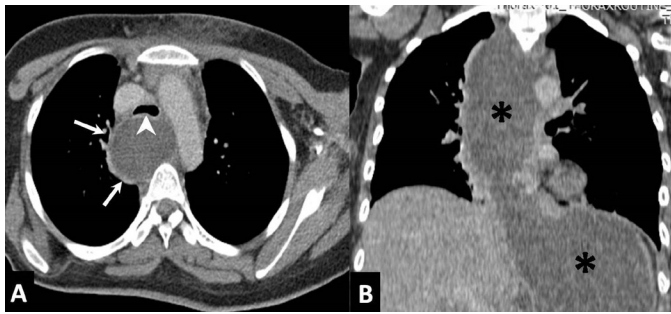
(A) Axial image of contrast enhanced CT scan shows a middle mediastinal cystic structure (arrows) compressing the trachea (arrow head). (B) Coronal reconstruction of the same shows the extent of oesophageal mucocoele, involving the stomach (asterisks).
